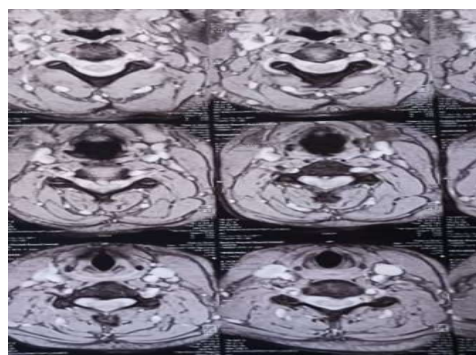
Case 4 Preoperative T2 MRI transverse view of cervical vertebrae
